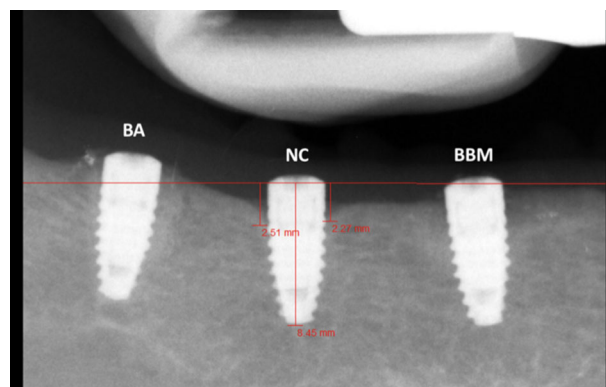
An example of standardized radiograph used for the radiographic analysis. Measurements were made as shown in the image (the middle implant). Implant length was measured in the image and was compared to the actual implant length reported by the manufacturer to account for the distortion of the image
